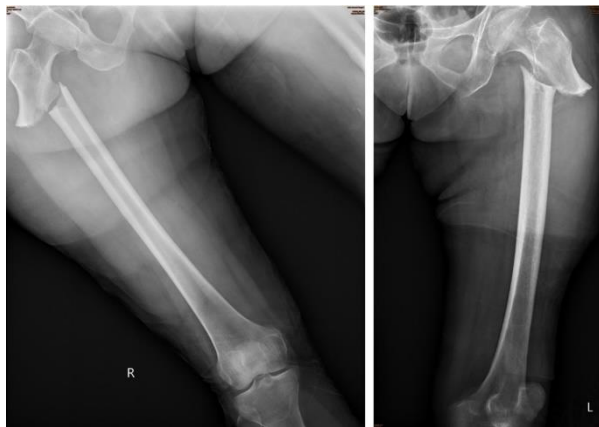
Example of bisphosphonate-related atypical femoral fracture (BPAFF) radiographs.
